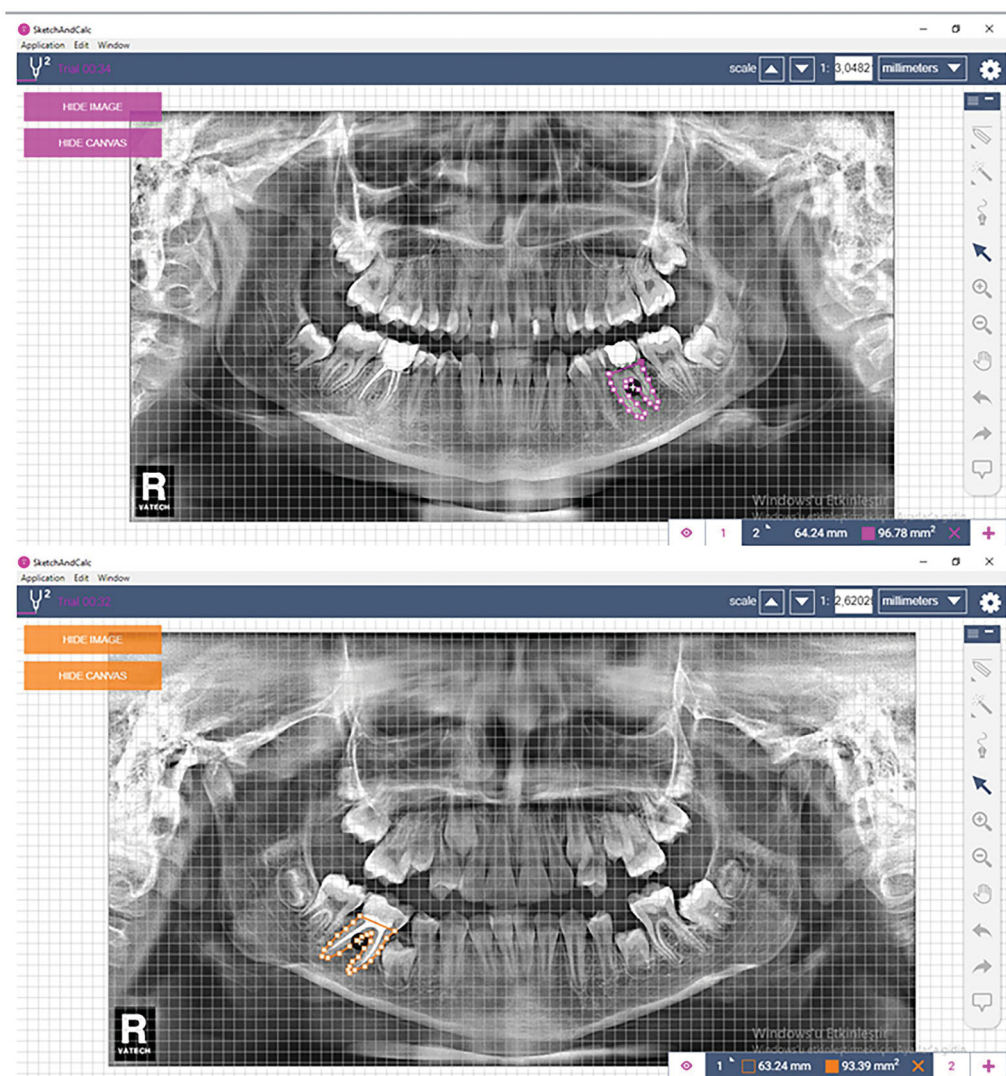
Area measurement of roots used in the study on panoramic radiographs.
